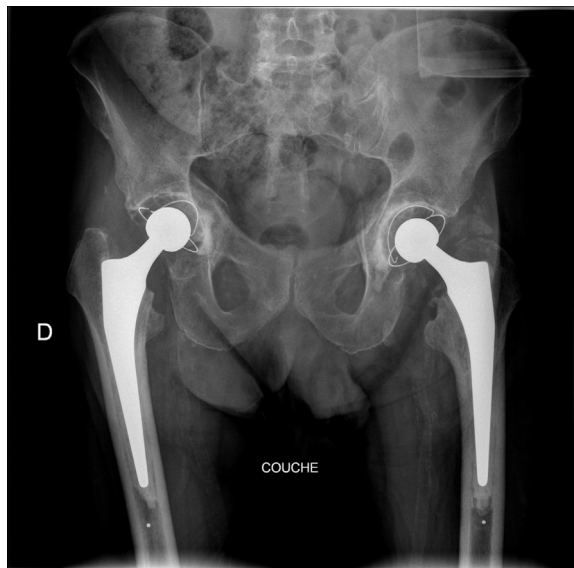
One year anteroposterior pelvis radiograph showing a hetero-topic ossification over the greater trochanter on the left side.
